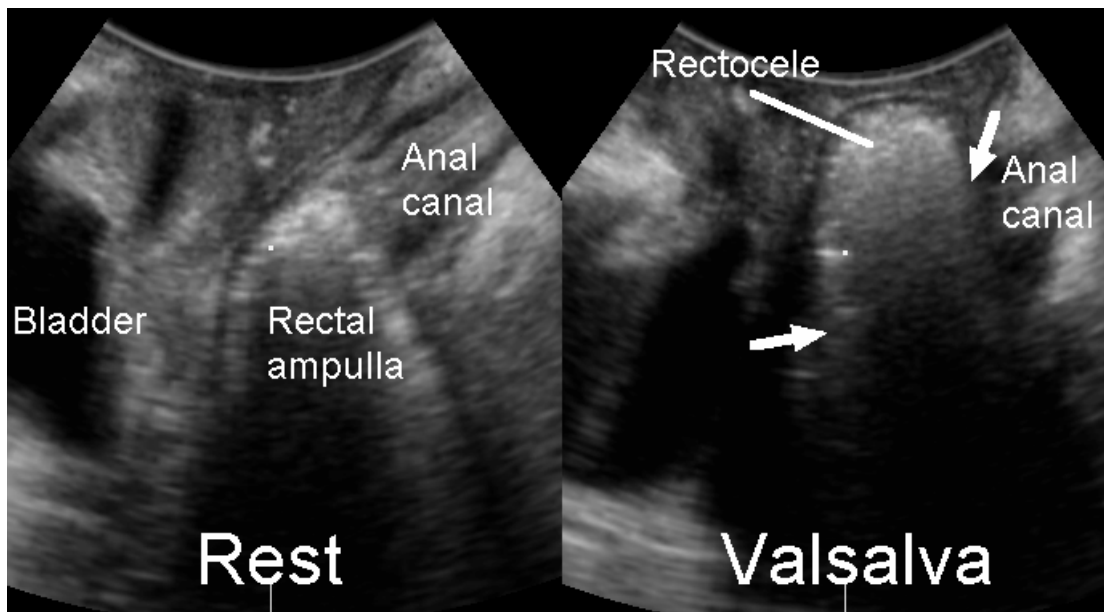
True rectocele, i.e., a defect of the rectovaginal septum with herniation of rectal mucosa and contents into the vagina, as diagnosed by translabial ultrasound. Midsagittal view at rest (left) and on Valsalva (right). The arrows indicate the margins of the herniation. The depth of this rectocele was measured at 18 mm.
